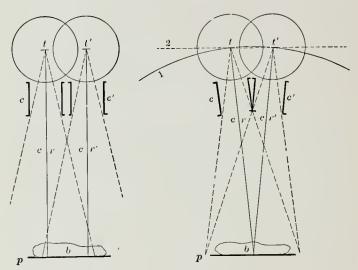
Lateral movement of tube (cylinders parallel). b, body to be x-rayed; p, photographic plate; t t', target; c c', cylinder; cr, cr', central rays.
